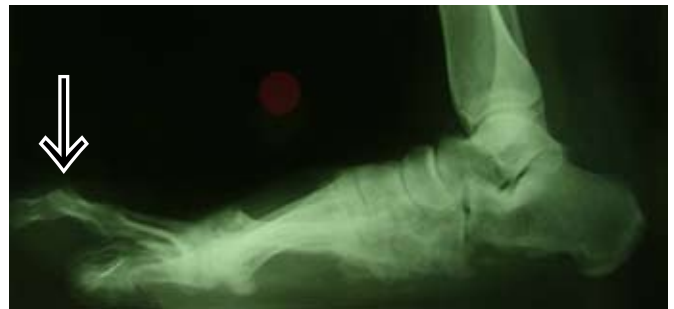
Frontal and lateral radiographs of the right foot showing macrodactyly (focal gigantism) of the 4th and 5th toes.
